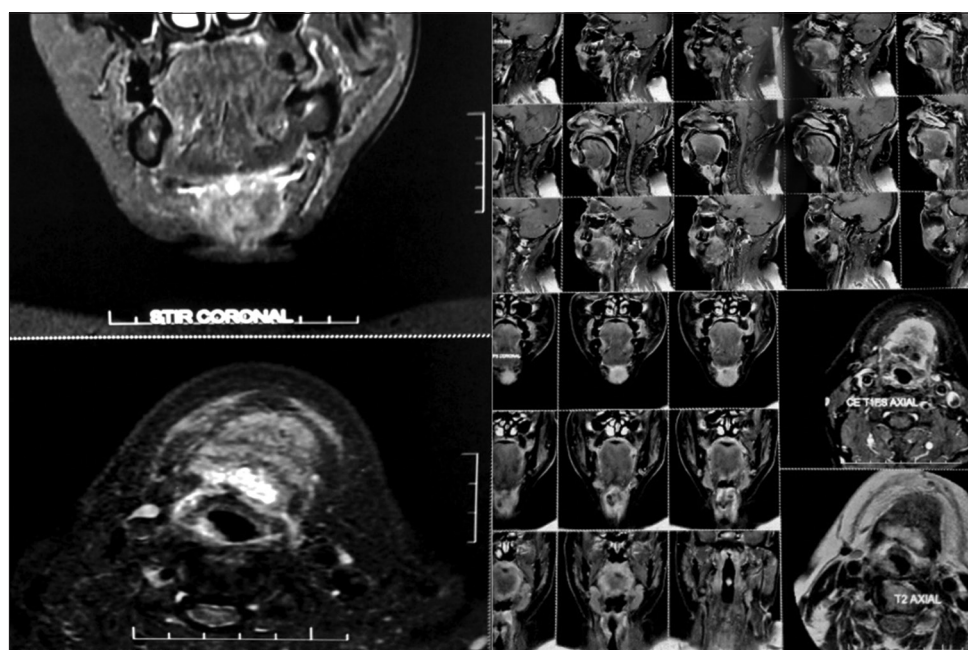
MRI shows an ill-defined heterogeneously enhancing soft-tissue lesion $39 \times 37 \times 24$ mm in midline in submental pre-hyoid region extending to anterior surface of thyroid cartilage which appears to be embedded in the left strap muscles.
